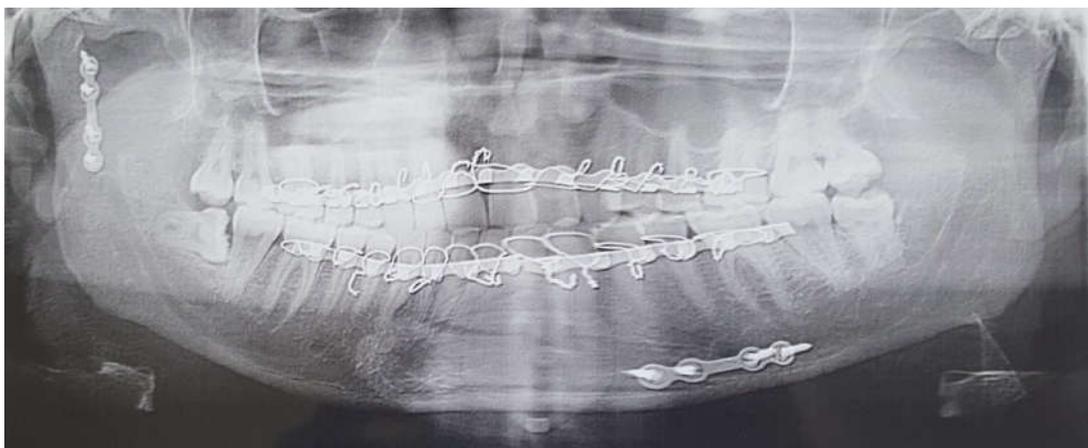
Showing post operative panoramic radiograph
